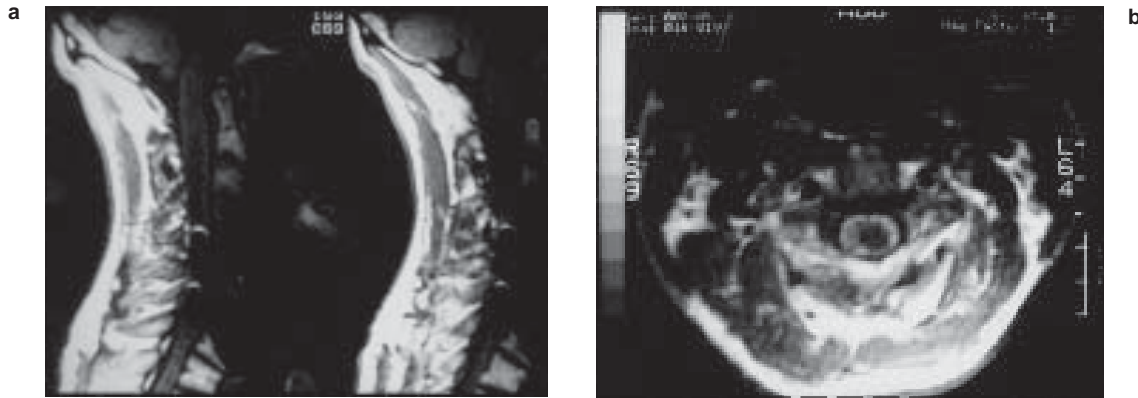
Acute posttraumatic syrinx. This 31-year-old male developed complete C-6 quadriplegia after diving into shallow water; a C-6 burst fracture was evident on radiographs. Initially, wrist extensor strength improved but then at 5 months began to deteriorate, worse on the left than the right. Motor evoked potential latencies to the left biceps and extensor carpi radialis longus became more prolonged. Magnetic resonance imaging revealed a large posttraumatic syrinx extending rostrally to the C-1 level (a) and more evident on the left (b). Shunting of the syrinx resulted in marked improvement of wrist extension strength and lessening of the patient's neck and arm pain.
